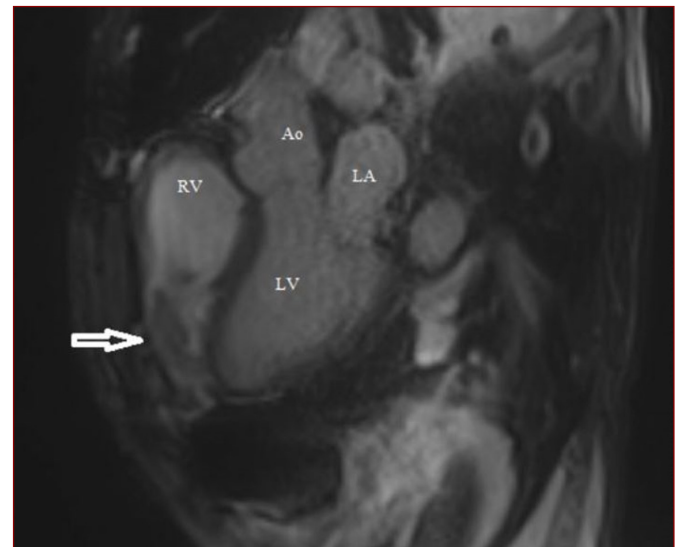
Cardiac MRI image of thrombus
